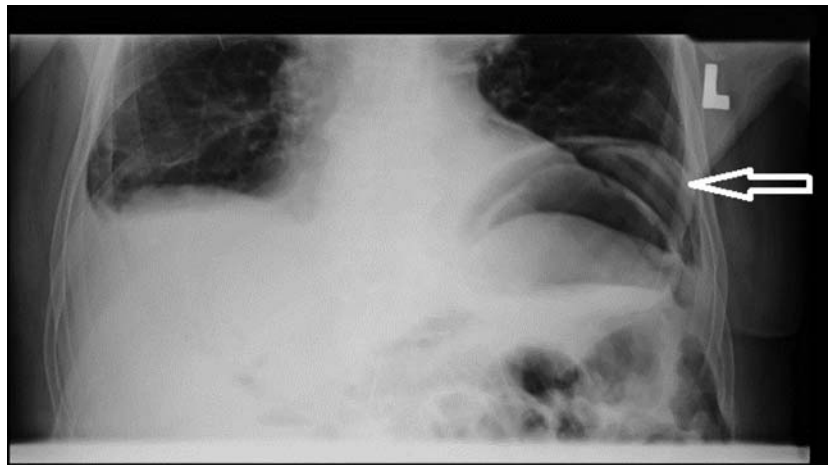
Abdominal X-ray in case 3 showing pneumoperitoneum in left subphrenic area (white arrow).
